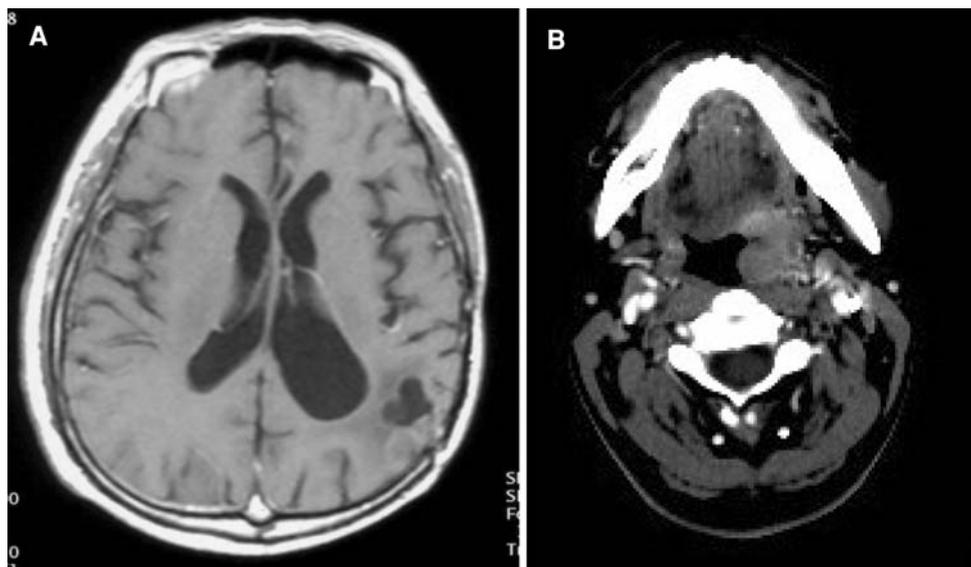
Long-term follow-up after surgical resection, radiotherapy, and TMZ (both concomitant and adjuvant) for over 6 years. a Brain MRI with contrast showing lack of recurrence 6 years post-resection. b Neck CT showing a left tonsillar mass with pathology consistent with squamous cell carcinoma
